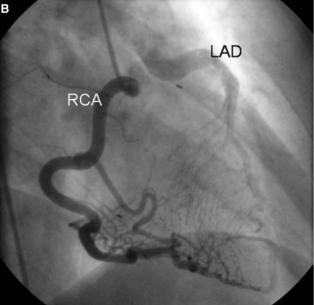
(A) Parasternal short axis view demonstrating an abnormal flow originating from the pulmonary artery (arrow). PA: Pulmonary artery, Ao: Aorta, LA: Left atrium. (B) Coronary angiography showing ectatic right coronary artery (RCA) giving collateral vessels to the left anterior descending (LAD) artery.
